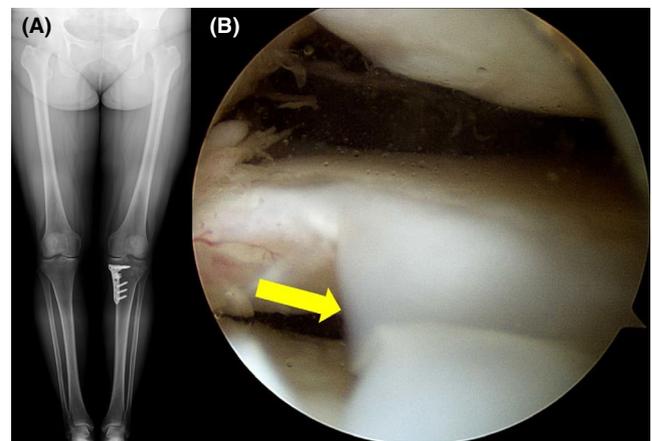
(A) A postoperative standing anteroposterior radiograph of the bilateral lower extremities reveals a hip-knee-ankle angle of -1.2° . (B) A second-look arthroscopic photograph shows regeneration of the lateral discoid meniscus (yellow arrow)
